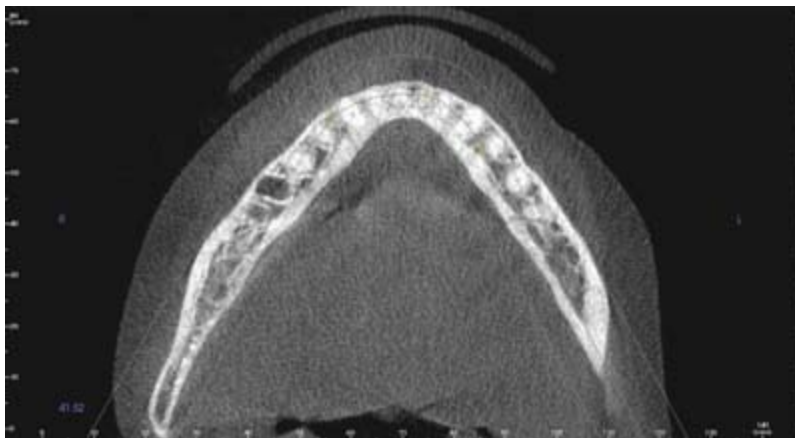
Axial CBCT image of mandibular arch demonstrates irregular medullary bone destruction and cortical defects from tooth #25 to tooth #31. There is new bone formation along the inferior facial cortex consistent with osteomyelitis and proliferative periostitis.
